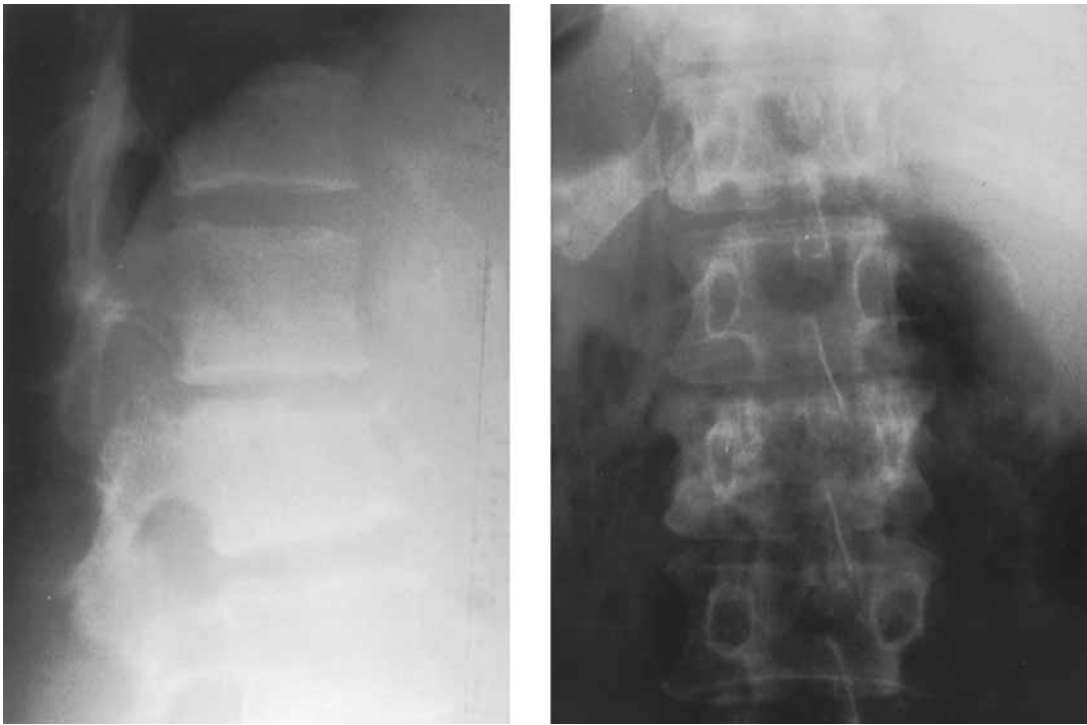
Lateral and AP radiographs showing an osteolytic lesion of the body of L2 with a hazy appearance of both pedicles. Involvement of the superior end plate of L2, and narrowing of the L1-L2 disc space.
